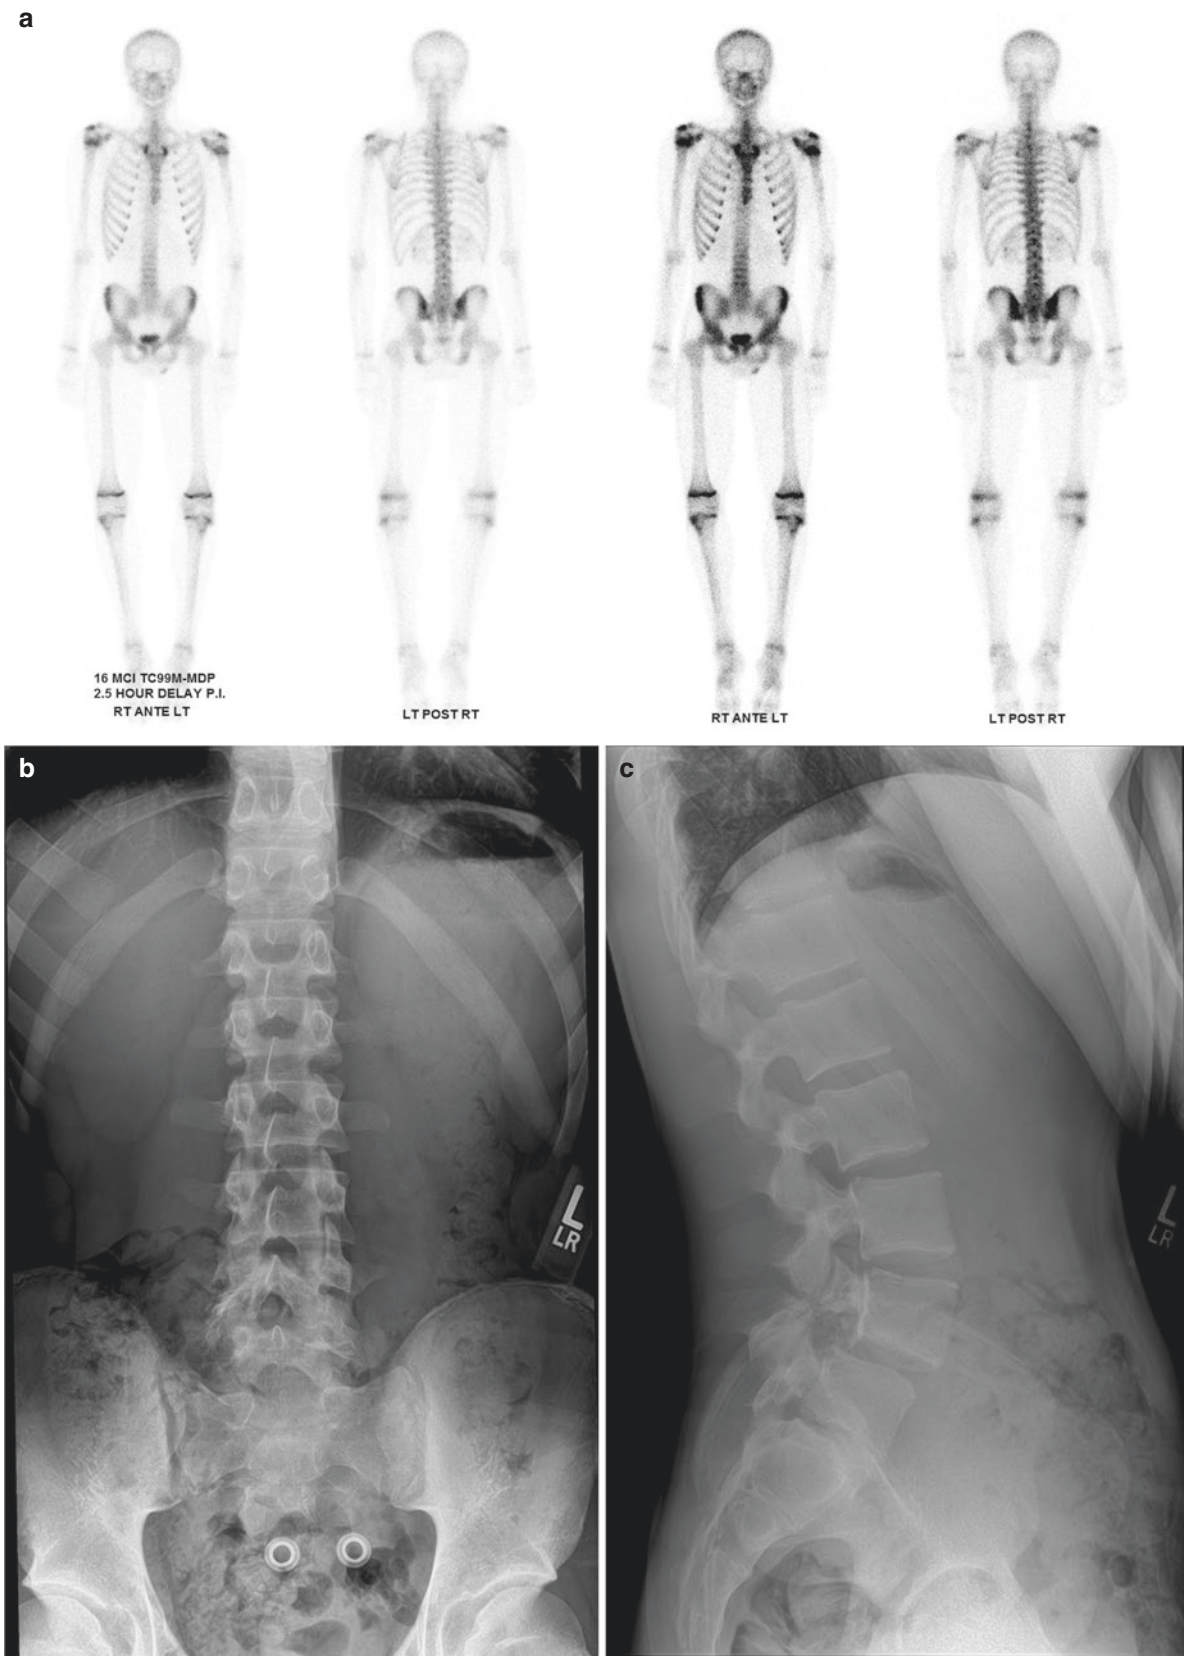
(a) SPECT scan in an 18-year-old baseball player with 9 months of low back pain that failed rest, which suggested increased uptake in the lower lumbar spine. Follow-up (b) AP and (c) lateral radiographs demonstrated L4 spondylolysis, and L4–L5 grade I isthmic spondylolisthesis. Preoperative (d) Axial and (e) sagittal CT, and (f)
